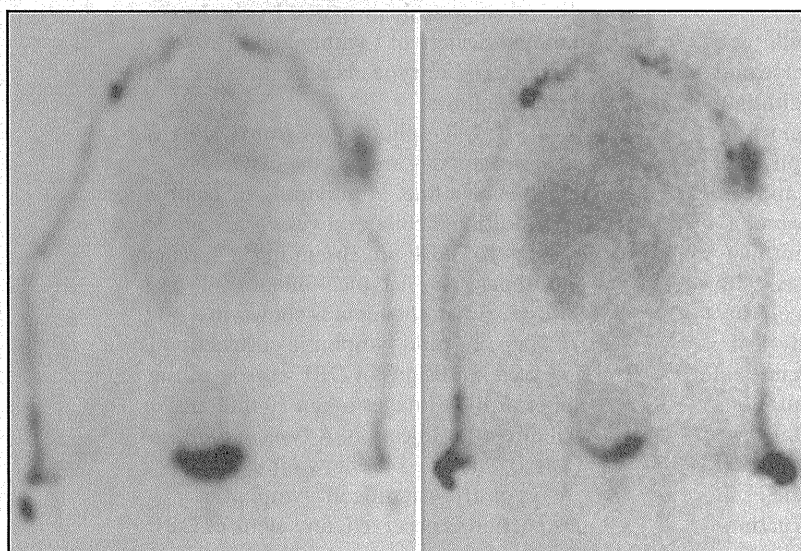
Lymphoscintigraphy images of a case of Type II-Subtype L lymphedema in the left arm. The left and right panels show images taken 30 and 120 min, respectively, after injection of a contrast medium. Lymph nodes around the clavicle were observed only on the image taken at the later time point. DBF was found only in the left upper arm.
